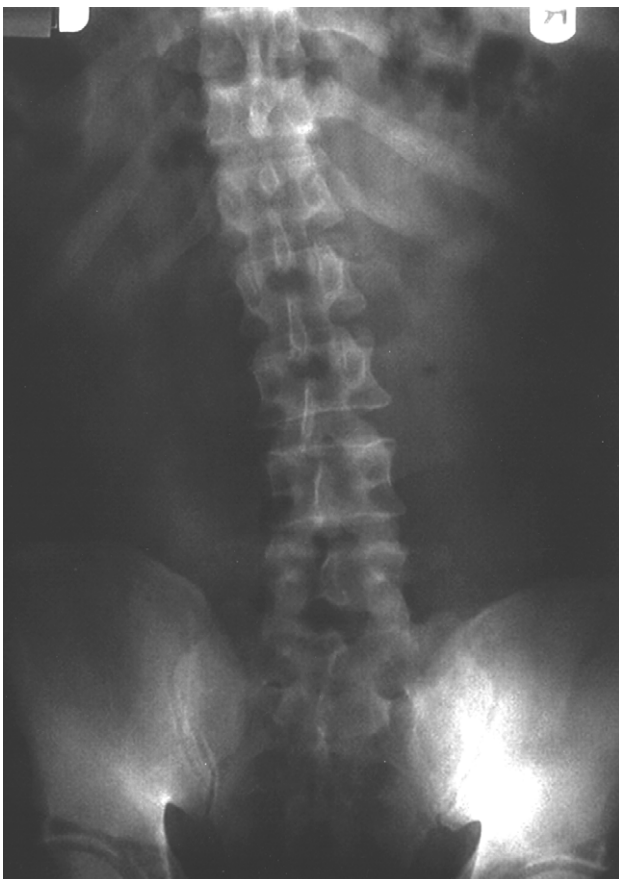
Anteroposterior radiograph of lumbar spine
